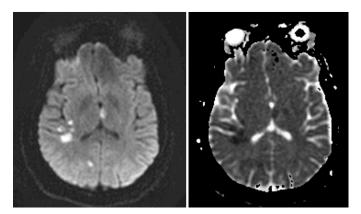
MRI brain diffusion imaging (DWI left, ADC on right) revealing diffusion-positive strokes in multiple vascular territories.
